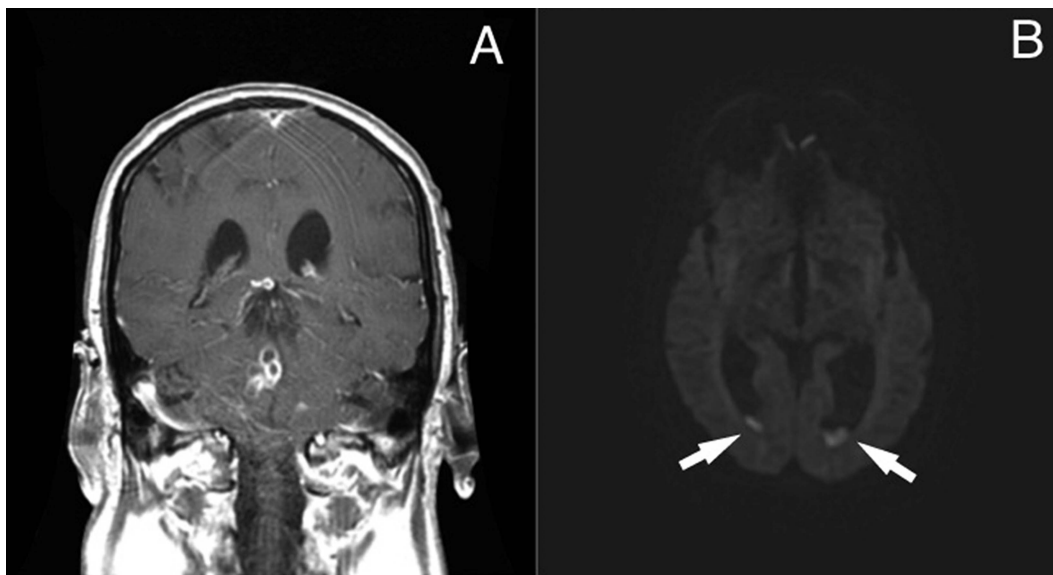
Coronal postcontrast T1 MRI (A) of the rim-enhancing multiloculated pontine abscess abutting the fourth ventricle at the time of initial presentation and axial diffusion weighted imaging (B) at the time of diagnosis demonstrating restricted diffusion within the posterior horns of the lateral ventricles (white arrows) consistent with intraventricular pus.
